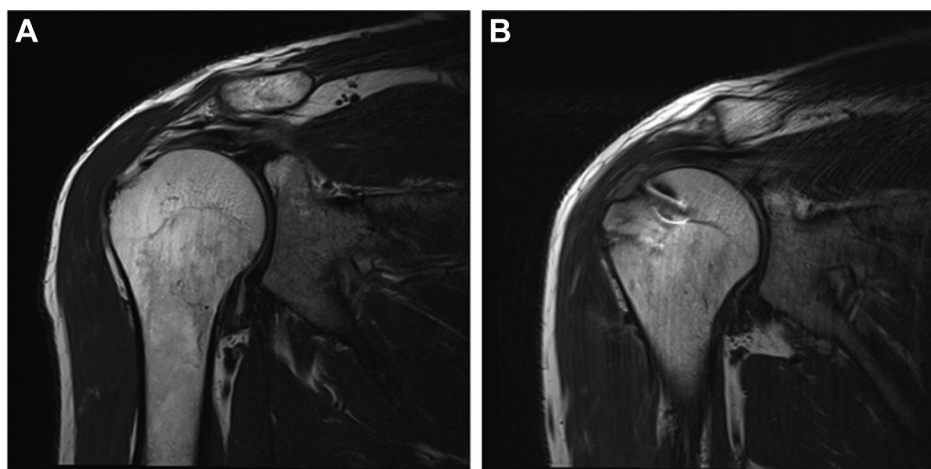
T2-weighted coronal view of the total rotator cuff tear. (A) Preoperative T2-weighted coronal view shows a supraspinatus total tear. (B) Postoperative T2-weighted coronal view shows complete healing of the greater tuberosity after a double-row repair.
